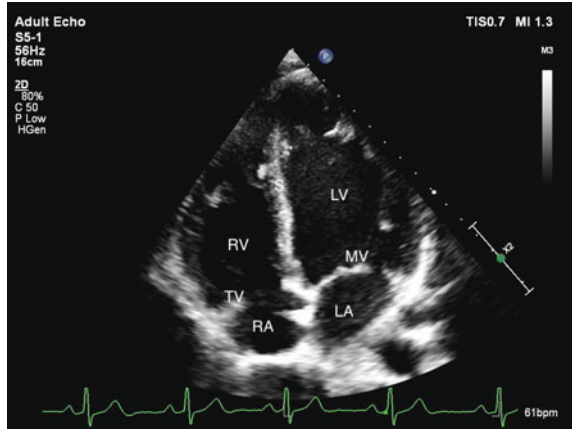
Sub-costal apical four-chamber view showing right atrium (RA), tricuspid valve (TV), right ventricle (RV), left atrium (LA), mitral valve (MV), left ventricle (LV) and septum (S)
